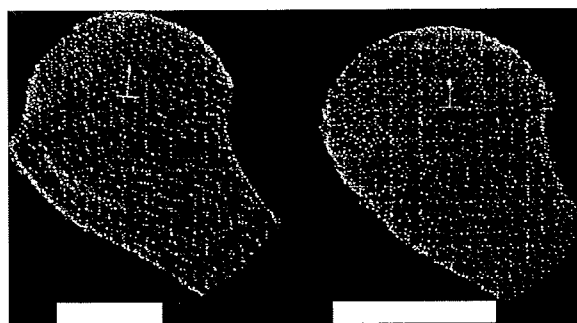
Surface geometry reconstructed from CT scans of humeral heads.
